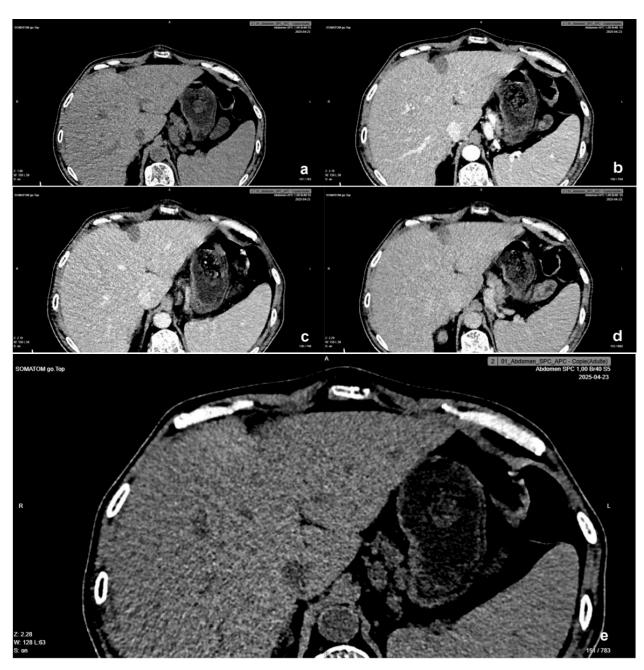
Axial CT slices without (a, e) and with contrast injection at arterial (b), portal (c), and delayed hepatic (d) phases, showing a rounded, well-circumscribed anterior subcapsular cystic lesion in segment IVa spontaneously hypodense (a) and heterogeneous due to dependent material isodense to the parenchyma (e), without enhancement at any post-contrast phase.
